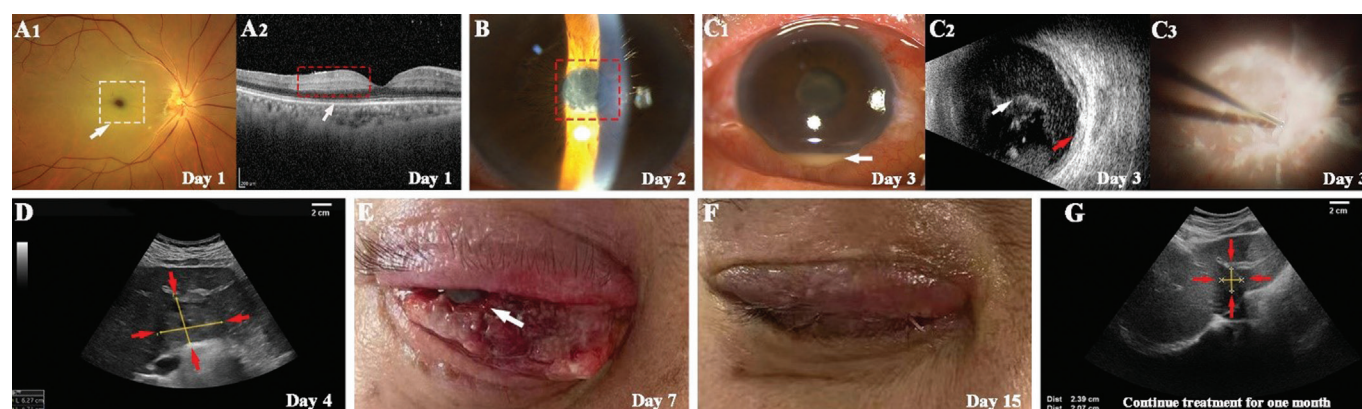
A case of *Klebsiella pneumoniae* endophthalmitis following CRAO A1: On day 1, funduscopy examination of the right eye revealed a cherry-red spot at the macula surrounded by a pale retina (white arrow), a hallmark of CRAO. This indicated significant retinal ischemia and hypoxia. A2: Optical coherence tomography (OCT) scan of the right eye demonstrated increased thickness of the inner retinal layers (white arrow), further confirming the diagnosis of CRAO. B: On day 2, closer view of the anterior chamber showed some fibrin and posterior synechia (red box) which indicated that the infection is beginning to spread. C1: On day 3, anterior segment photographs of the right eye showed marked conjunctival chemosis and hypopyon in the anterior chamber (white arrow); C2: Ultrasound B-Scan of the right eye showed dense opacity in entire vitreous (white arrow) and thickened chorio-retinal complex (red arrow), indicating vitreous exudates; C3: During the vitrectomy surgery, extensive superficial retinal exudates and vascular occlusion were visible, demonstrating the severity of retinal damage caused by the infection. D: On day 4, abdominal color Doppler ultrasound examination performed a 6.27 cm×4.74 cm complex mass in the right lower hepatic lobe (red arrow) which suggested a potential source of the bacterial infection causing endogenous endophthalmitis. E: On day 7, the infection had triggered corneal melting at the nasal scleral site (white arrow), a severe complication of endogenous endophthalmitis that risks globe perforation. F: On day 15, after removing the damaged eye through evisceration, the patient's right eye showed markedly reduced eyelid swelling and conjunctival congestion, indicating a significant decrease in inflammation. G: One month after discharge, abdominal color Doppler ultrasound examination showed improvement in the previously identified liver abscess area (red arrow) which suggested successful treatment of the underlying infection. CRAO: Central retinal artery occlusion.
